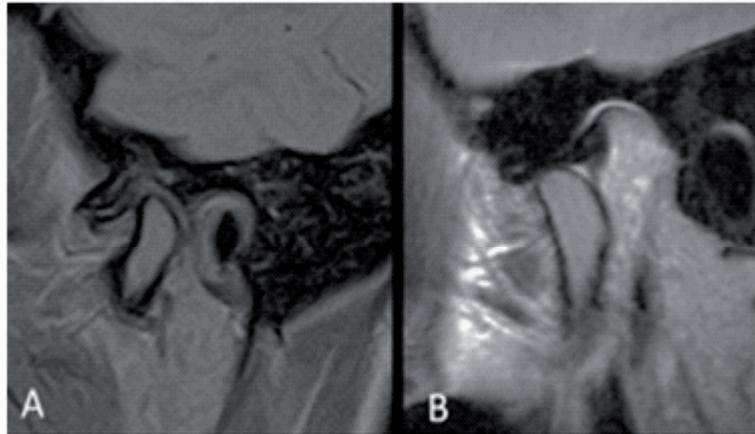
Sagittal images on MRI showing TMJ disc displacement with reduction (DDR): A) closed mouth; B) open mouth
